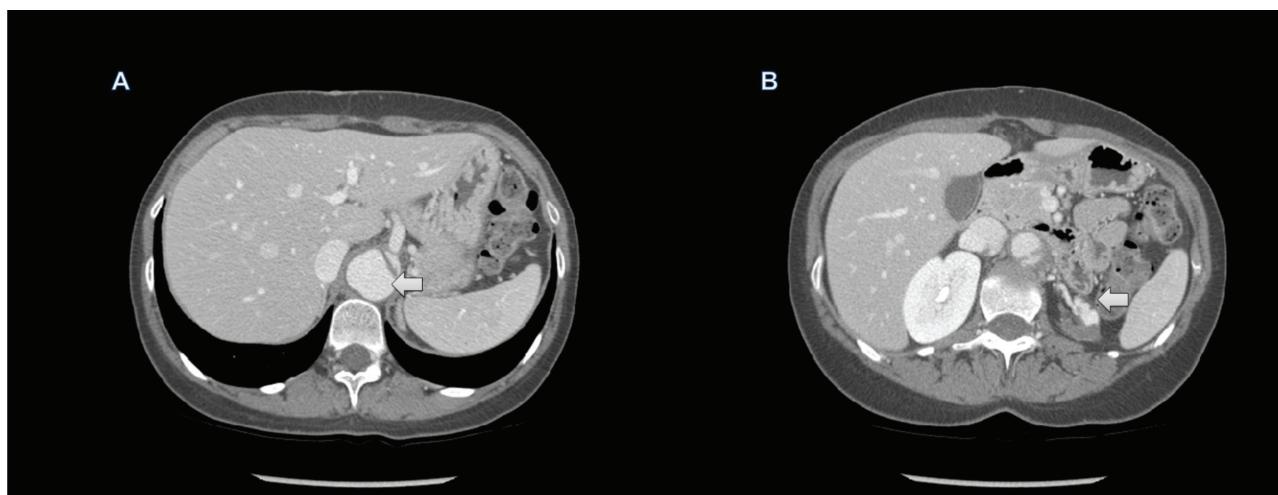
Contrast enhanced abdominal computed tomography scan (six months after the surgery, axial views): A) the dissected aorta (big arrow), B) atrophy of the left kidney (big arrow) and resolution of the retroperitoneal hematoma.
